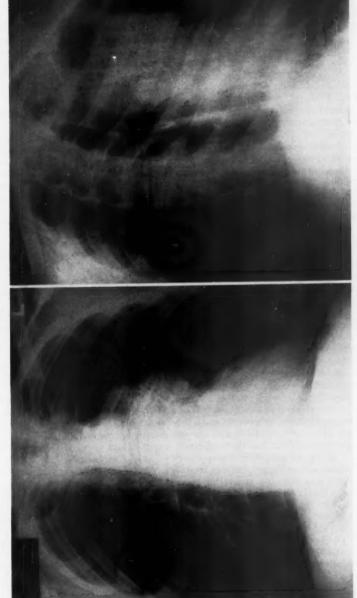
A. Posteroanterior, and B. left lateral roentgenogram of chest showing left hilar mass (thymoma) in anterior superior mediastinum.
